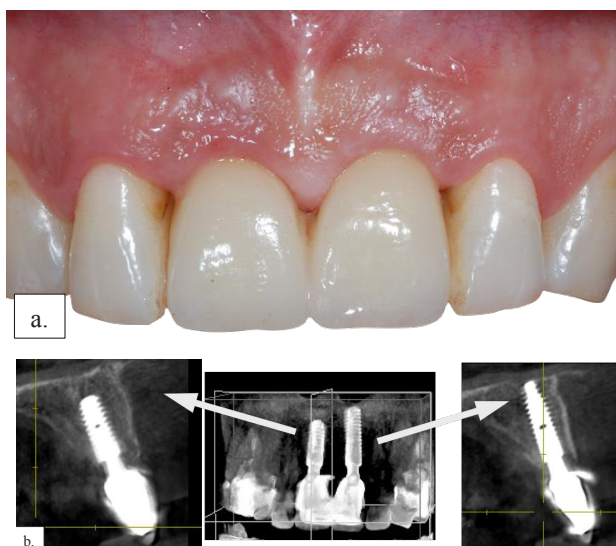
a): view of definitive crowns 6 months after surgery; b): cone beam of elements 1.1 and 2.1 6 months after surgery.
